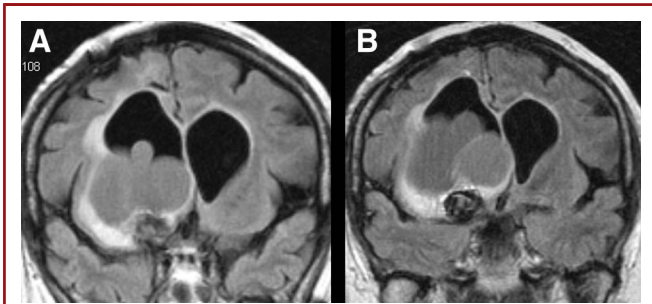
Magnetic resonance image follow-up at 20 (A) and 27 (B) months postoperatively showing growth of the expansive process around the previously coiled aneurysm with surrounding edema of the brain tissue, causing midline shift (coronal sections).
